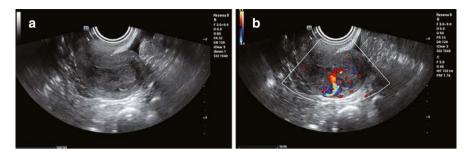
(a) Ultrasound shows a thickened endometrium with uneven echogenicity and the absence of a clear boundary between the endometrium and the myometrium of the anterior wall. (b) Color Doppler shows abundant blood flows within the endometrium, predominantly derived from the myometrium of the anterior uterine wall. Pathological examination confirmed EC with myometrial infiltration
